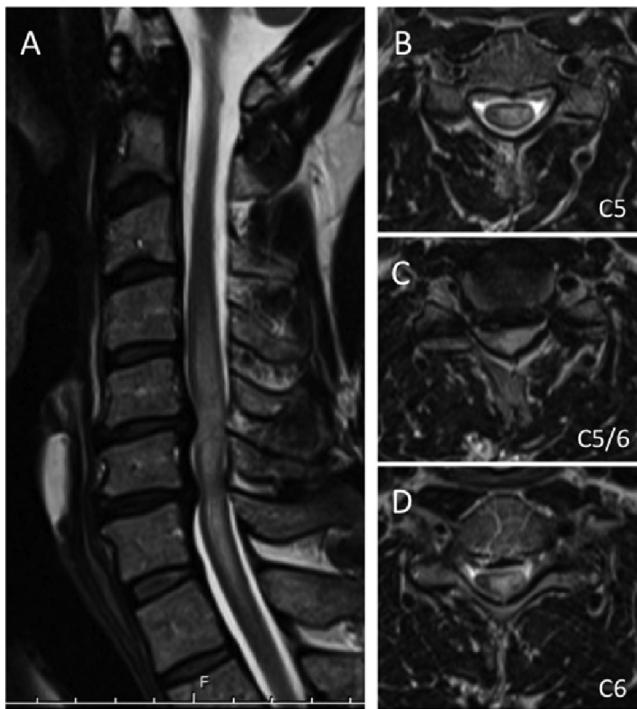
Cervical magnetic resonance (MR) images after rapid deterioration. (A) Sagittal images demonstrate marked expansion of T2-weighted high-signal intensity area although the extent of cord compression did not change. (B–D) Axial images demonstrate T2-weighted high signal intensity area, which is mostly located in the gray matter.
